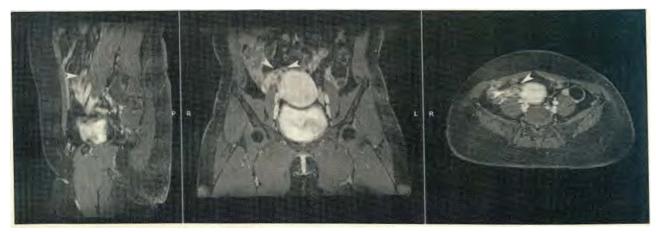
MRI of the pelvis: To the right, it is contiguous with what appears to be the globe-shaped uterus. No definite canal is seen. The endometrial canal is not clearly identified. The uterus itself measures $8.4 \text{cm} \times 7.1 \text{cm} \times 6.5 \text{cm}$ (CC x W x AP) and exhibits heterogeneous, predominantly T1W-/T2W-isointense (to muscle) signals with restricted diffusion. Several small foci of T1W-/T2W-hyperintensity are seen within the uterus. No magnetic susceptibility artifact identified.
